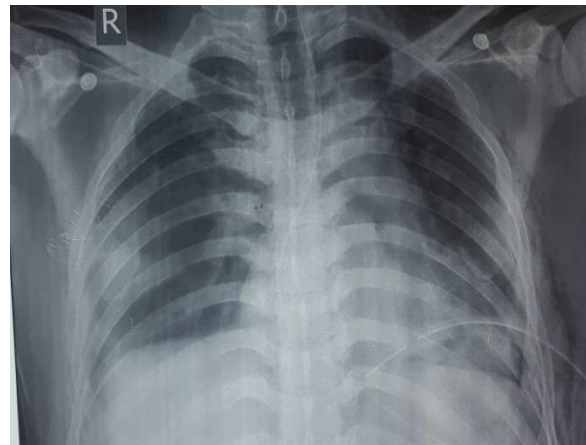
Post operative Chest X-ray of same patient showing normal appearance of both hemidiaphragm.
